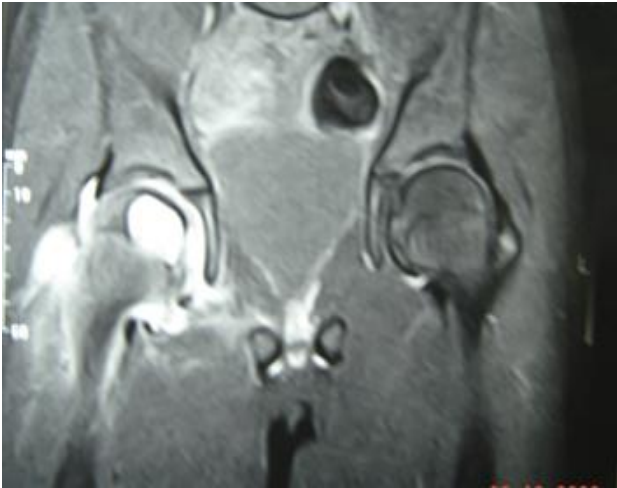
MRI of T2 hyperintensity with joint effusion.
